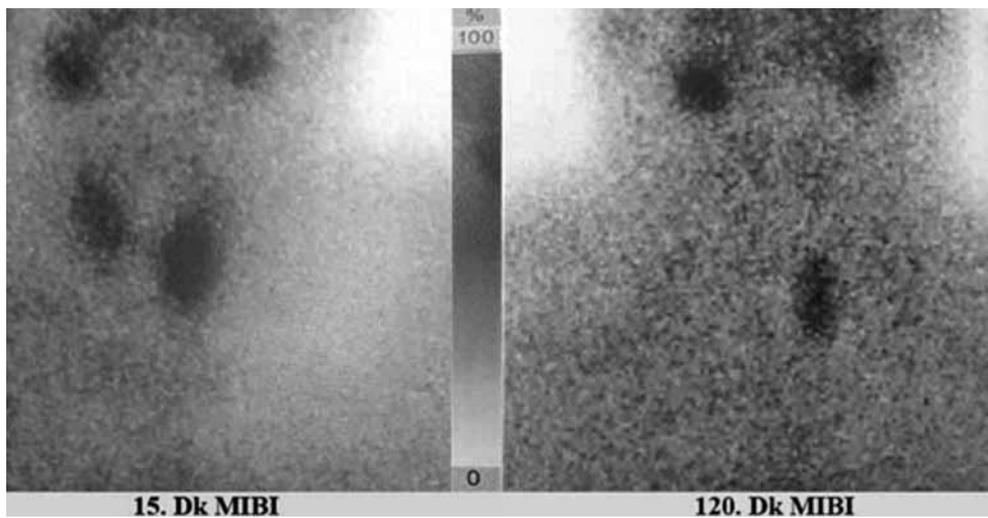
Technetium-99m-labelled sestamibi imaging with single photon emission computed tomography of adenoma (9<sup>th</sup> patient).
